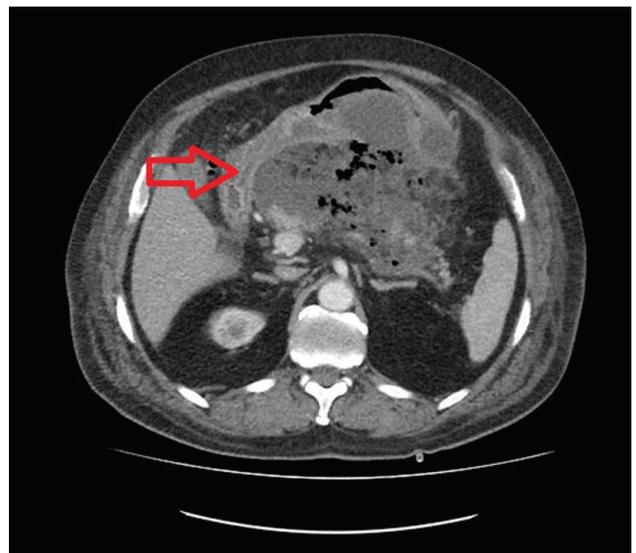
Walled-off pancreatic necrosis observed with computed tomography (red arrow).
